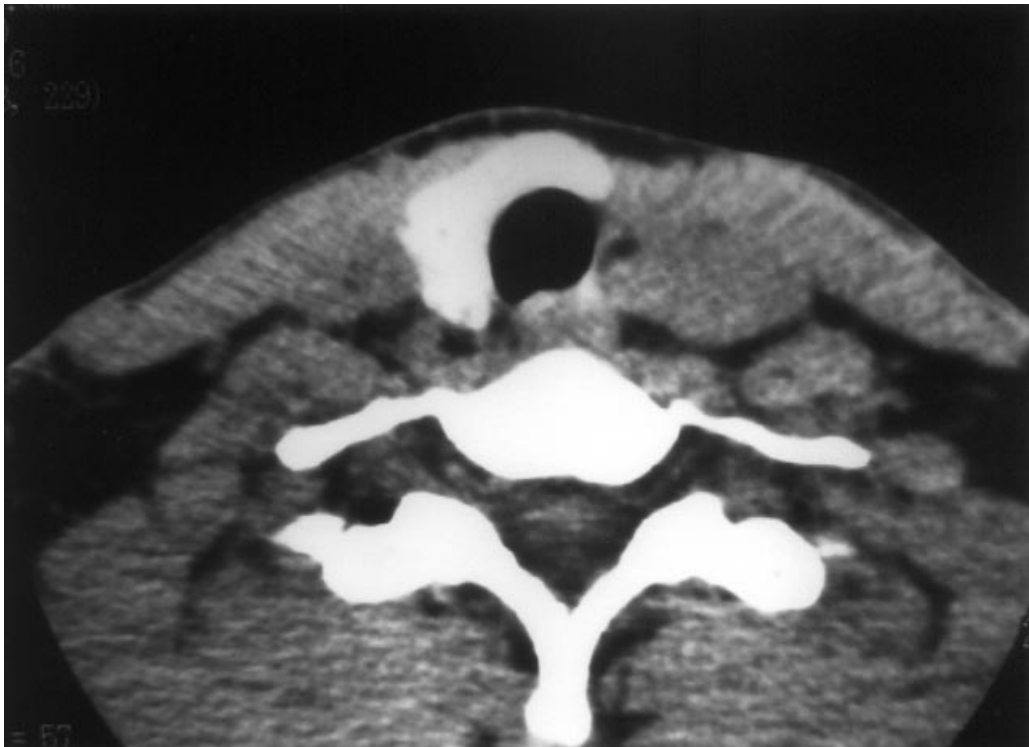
CT shows right lobe and isthmus.
